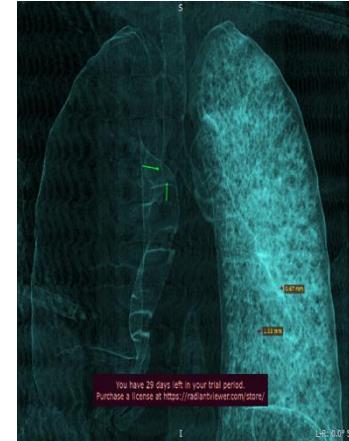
The coronal 3 D of CT shows a pneumothorax on the right side and non-specific trauma-associated alterations in the right proximal bronchus tree.
